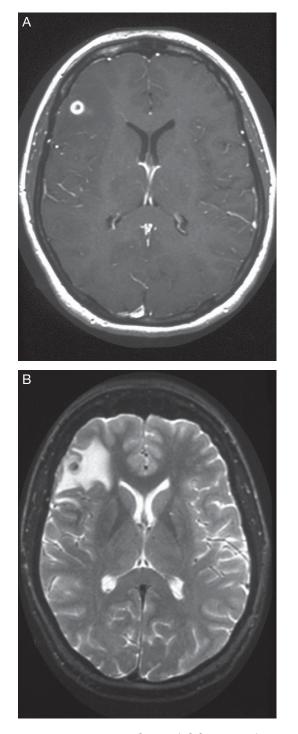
Cysticercosis Abscess (Globose Form). A, Magnetic resonance image (MRI) (T1-weighted, gadolinium-enhanced image) demonstrates a ring-enhancing lesion in the right frontal lobe with associated edema. This suggests a host immune response to a live or dying organism. B, The surrounding edema demonstrated on T2-weighted MRI has a similar implication.
